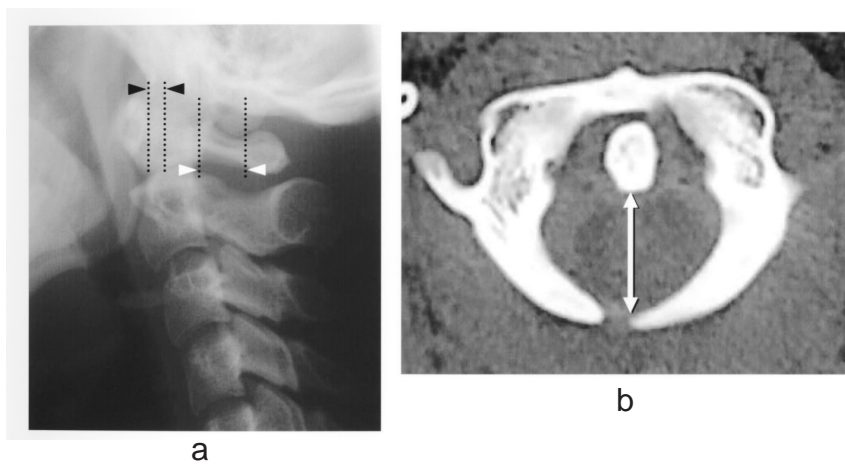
a Case 2 : A lateral radiograph of the cervical spine, showing hypoplasia of the atlas ; the anterior atlantodens interval was 2 mm (black arrowheads), whereas the space available for the cord was 12 mm (white arrowheads).
